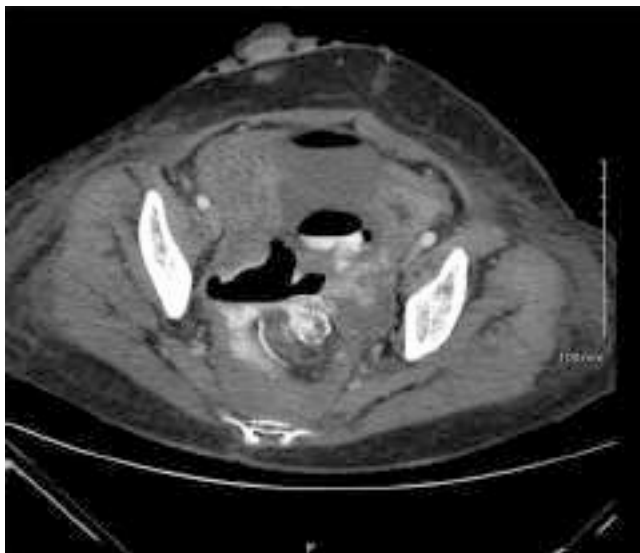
CT scan in a patient with anastomotic leak after low anterior resection.
